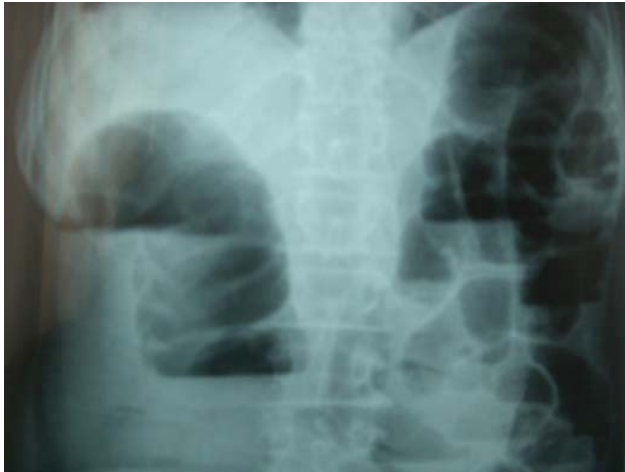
Plain abdominal X-rays were first obtained in patient with acute symptoms, which revealed air-fluid levels suggestive of intestinal obstruction.
